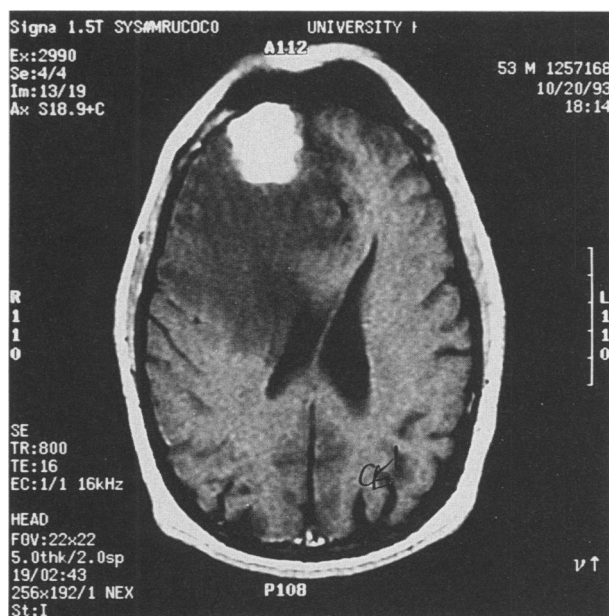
Frontal lobe tumor. Patient 3 was profoundly depressed preoperatively, but after surgical removal of his enhancing 3-cm right frontal pole metastasis, he was greatly improved. The large area of surrounding edema on this enhanced T1-weighted magnetic resonance imaging scan further compromised the right frontal lobe and added to his neurobehavioral deficit (TR = 800 msec, TE = 16 msec).
